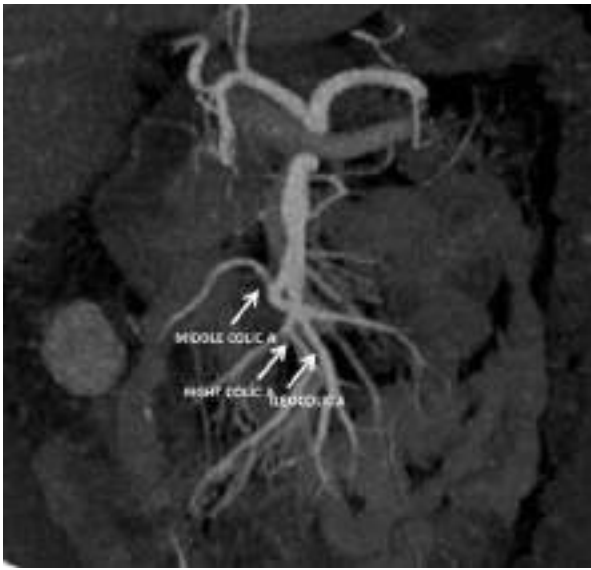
Main branches of the superior mesenteric artery. Coronal contrast-enhanced MIP CT image (arterial phase).
